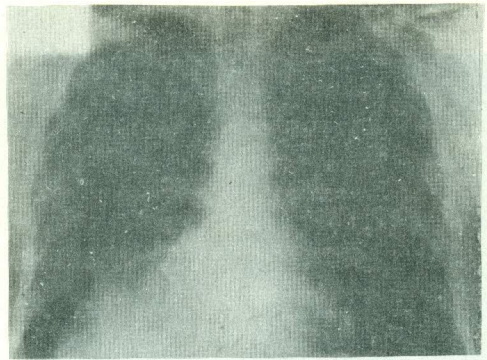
X-ray chest showing LT. pleural effusion with pleural thickening in a case of malignant pleural mesothelioma.
